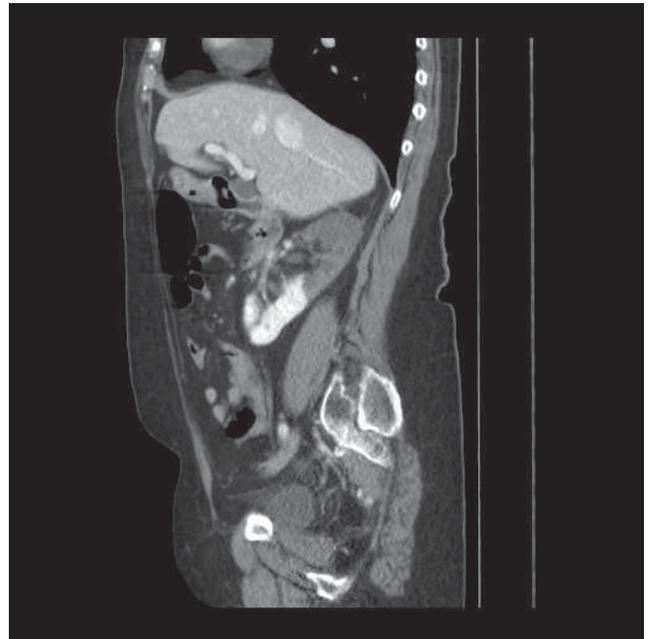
Contrast-enhanced abdominal CT (coronal vue): several hypodense areas in the upper two thirds of the right kidney.
